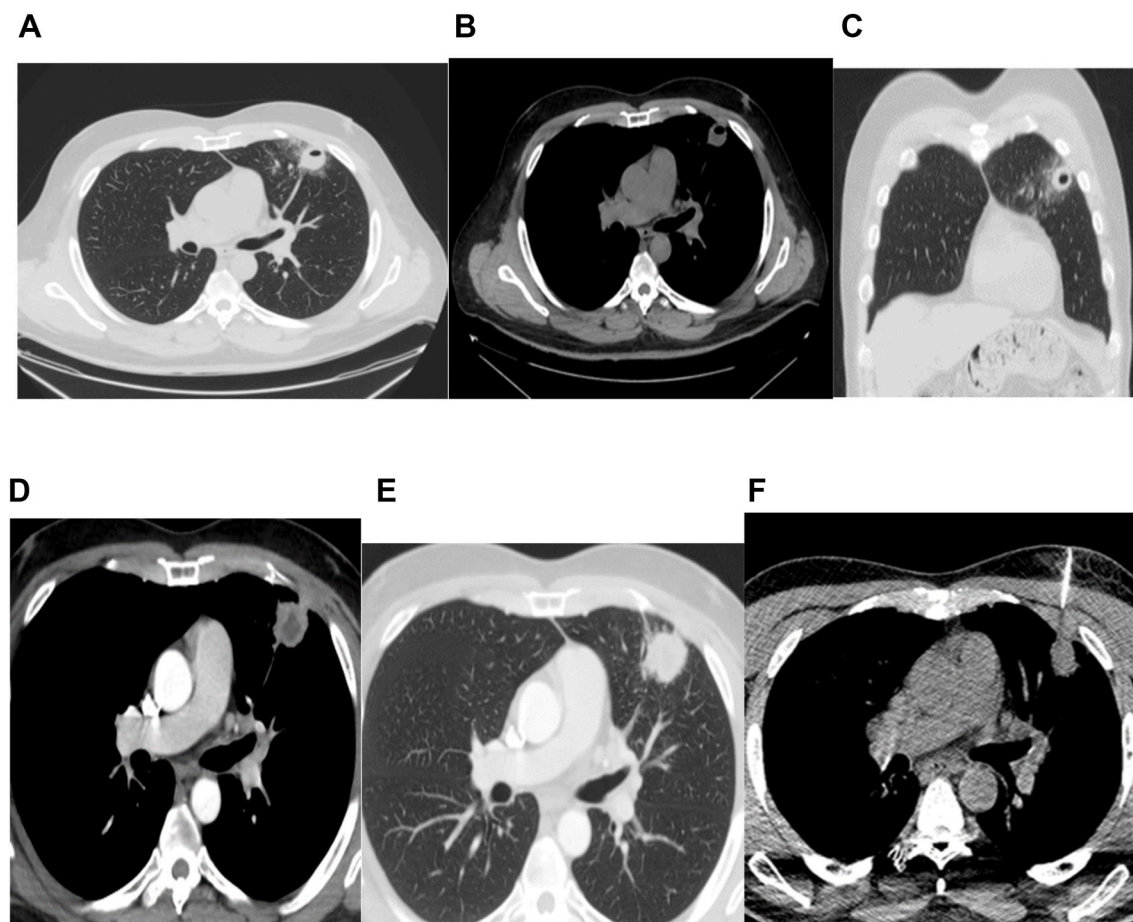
CT thorax lung window, 2b mediastinal window, 2c lung window coronal section 23-August-2021: A 2.2×2.5 cm subpleural cavity nodule is seen in the anterior aspect of the left upper lobe/lingula, with an adjacent area of patchy ground glass opacity, minimal interlobular septal thickening, and tree-in-bud nodules.
